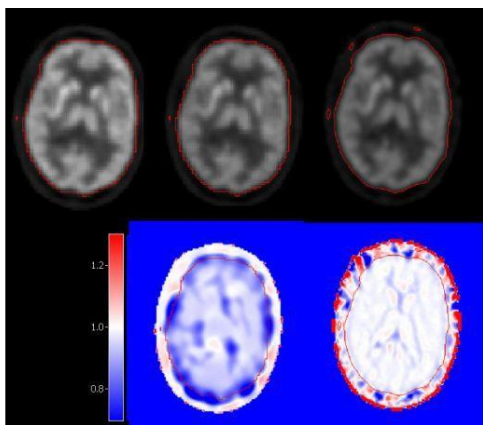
Top row: OSEM using CT based AC (left), OSEM using MR-AC (middle), TF-MLAA using MR-AC (right). Bottom row: Ratio images of OSEM-MRAC divided by OSEM-CTAC (left) and TF-MLAA using MR-AC divided by OSEM-CTAC (right). Blue indicates areas with more than -20% bias, white areas with less than + or - 5% bias and red indicates areas with more than +20% bias
